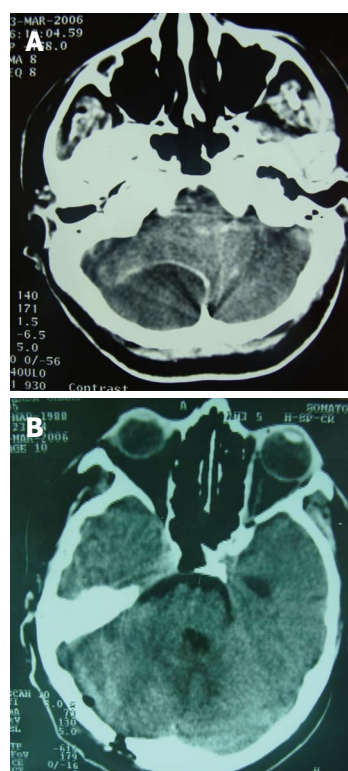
Computed tomography. A: Head computed tomography showing subdural empyema of right cerebellar convexity; fourth ventricle compression and occlusion; B: Burr hole on the right occipital infratentorial convexity; reappearance of fourth ventricle; complete evacuation of subdural cerebellar empyema.
